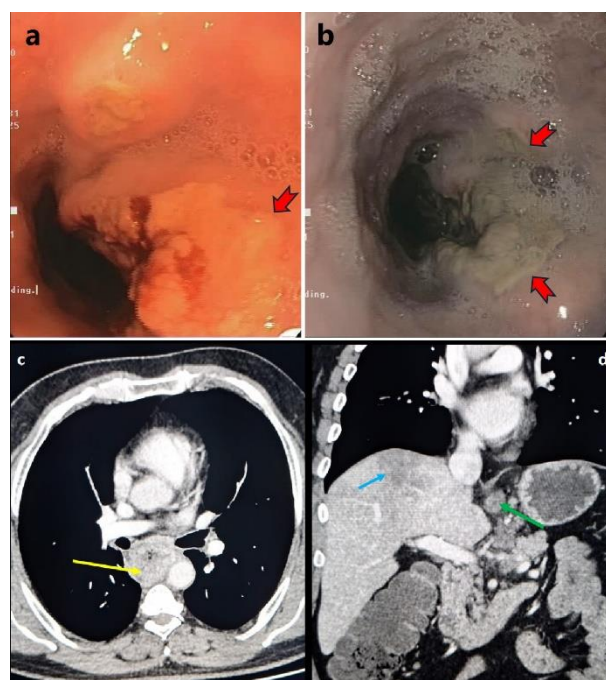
(a, b) Endoscopic images demonstrating the eccentric, esophageal ulceroproliferative lesion (red arrows). (c) The axial CT image reveals asymmetrical circumferential wall thickening involving the mid and lower third of the esophagus (yellow arrow). (d) The coronal CT images reveal an irregular hypodense peripherally enhancing lesion in the right lobe of the liver (blue arrow) and enhancing gastrohepatic lymph nodes (green arrow).
